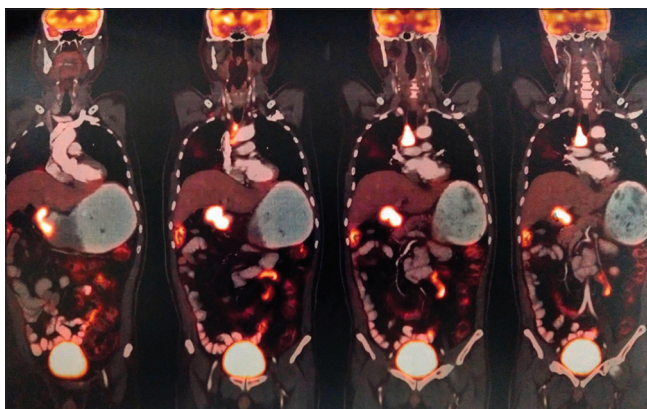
PET-CT shows a hypermetabolic malignant mass in the antrum of the stomach extending into the first part of the duodenum
